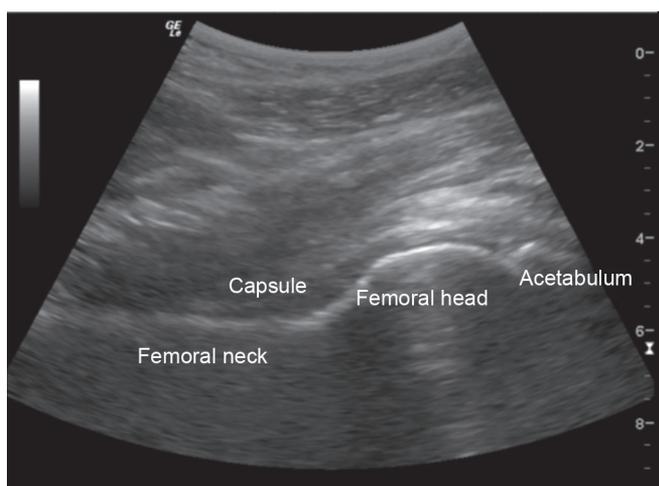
Ultrasound image of hip
